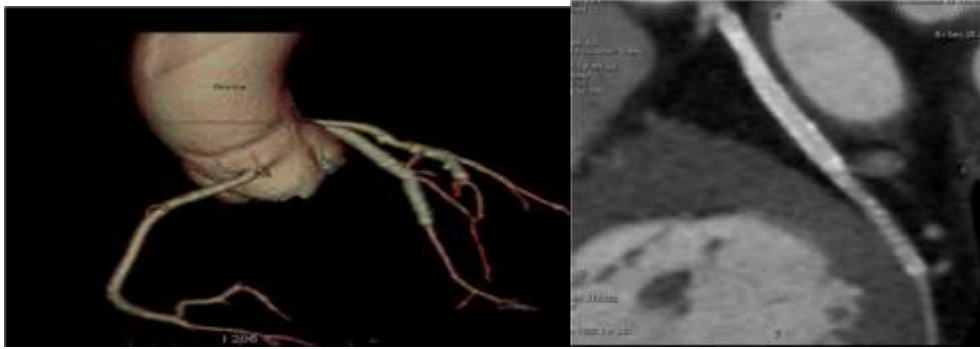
Shows Coronary CT angiography male 54 year Rt 3D volume rendering image, and Lt curved multi planar reformatted (MPR), three stent placed in LAD and left circumflex.CAC score is 28.In the proximal part of the LAD showed athermanous plaque with stenosis of the distal part of the left circumflex
